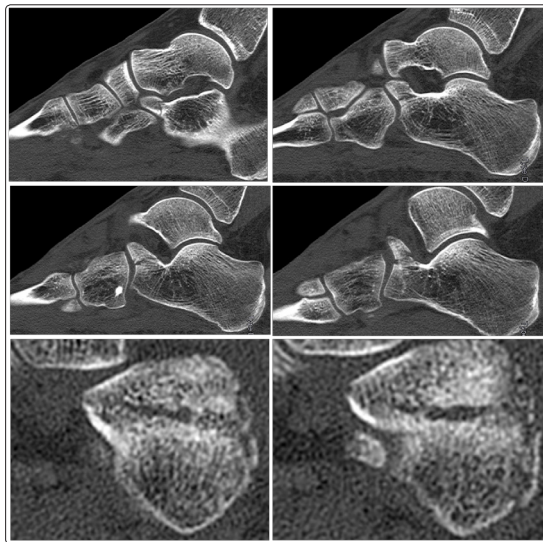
CT scans show the involvement of the articular surface with joint depression
